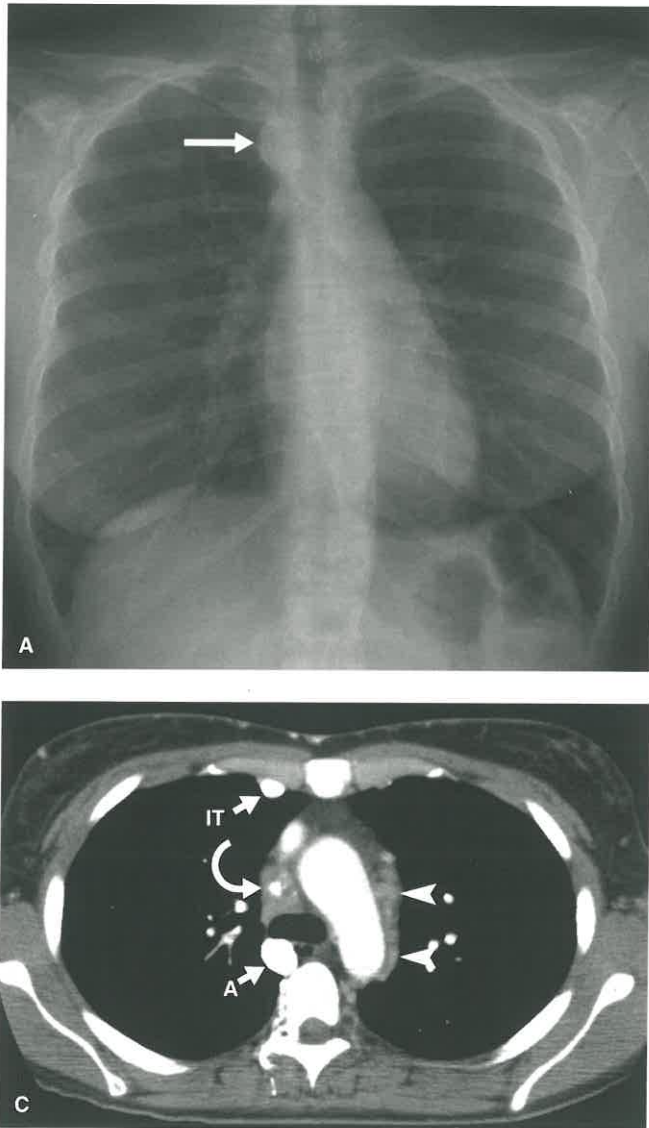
Fibrosing Mediastinitis From Histoplasmosis. A: Posteroanterior chest radiograph in an asymptomatic 33-year-old woman shows calcifications in the right paratracheal region (*arrow*). B, C: Axial contrast-enhanced CT scan at the level of the aortic arch demonstrates calcified right paratracheal nodes (*arrows* in B) with calcified thrombosis of the superior vena cava (*curved arrow* in C) and dilated right internal thoracic (IT), azygos (A), and subcutaneous venous collaterals. Note lobulated dilatation of the unenhanced left superior intercostal vein (*arrowheads* in C) along the aortic arch representing additional mediastinal venous collaterals.
